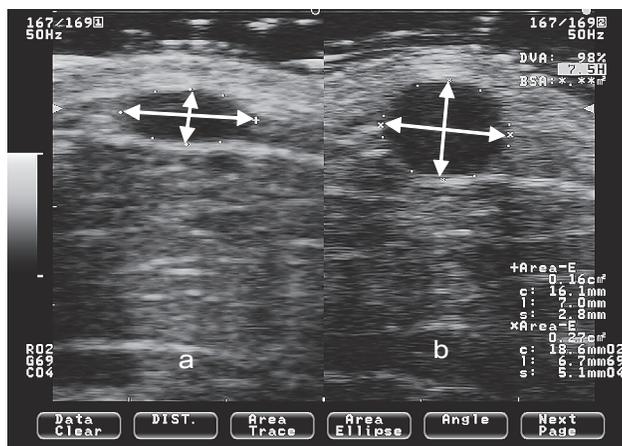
A subject's ultrasound image (B-mode picture) of the median cubital vein, before (a) and after (b) tourniquet application at 60 mmHg for 60 sec.
